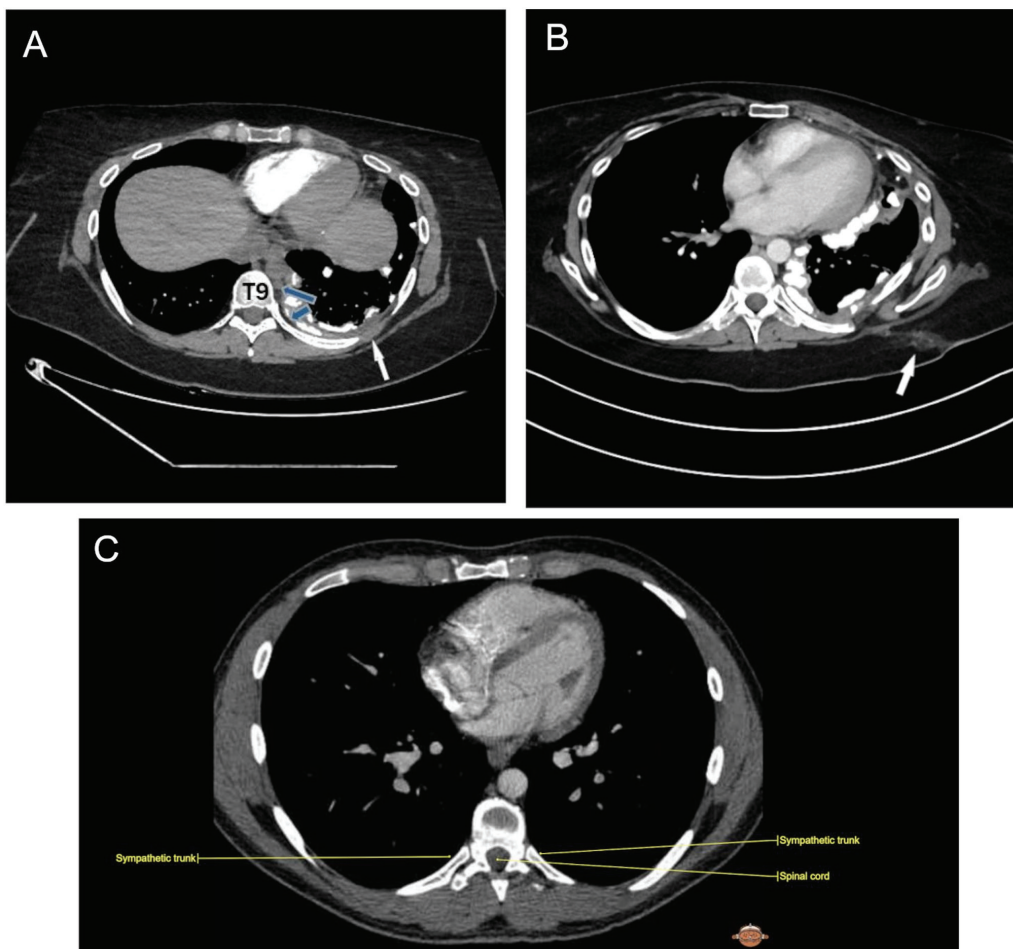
(A) Pre-operative contrast-enhanced CT image, axial section soft tissue window, demonstrates circumferential and nodular pleural thickening (white arrow) predominantly along the left lateral pleural space including mediastinum pleural surface along with extensive calcifications, representing osteosarcoma pleural metastasis; blue arrows reveal sympathetic chain. (B) Post-operative contrast-enhanced CT image, axial section soft tissue window, demonstrates post-operative changes in the subcutaneous fat of the left hemithorax (arrow) in 8th to 9th intercostal space. (C) Anatomic image of sympathetic track in 8th intercostal place; Courtesy of IMAIOS © 'Micheau A, Hoa D, e-Anatomy, www.imaios.com, DOI: 10.37019/e-anatomy'. CT, computed tomography.
